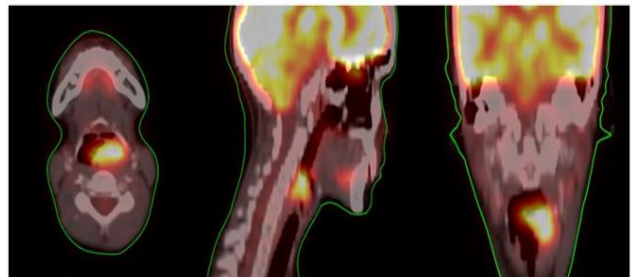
shows the PET CT scan of 21 year old female with squamous cell carcinoma of larynx in axial, sagittal and coronal views
